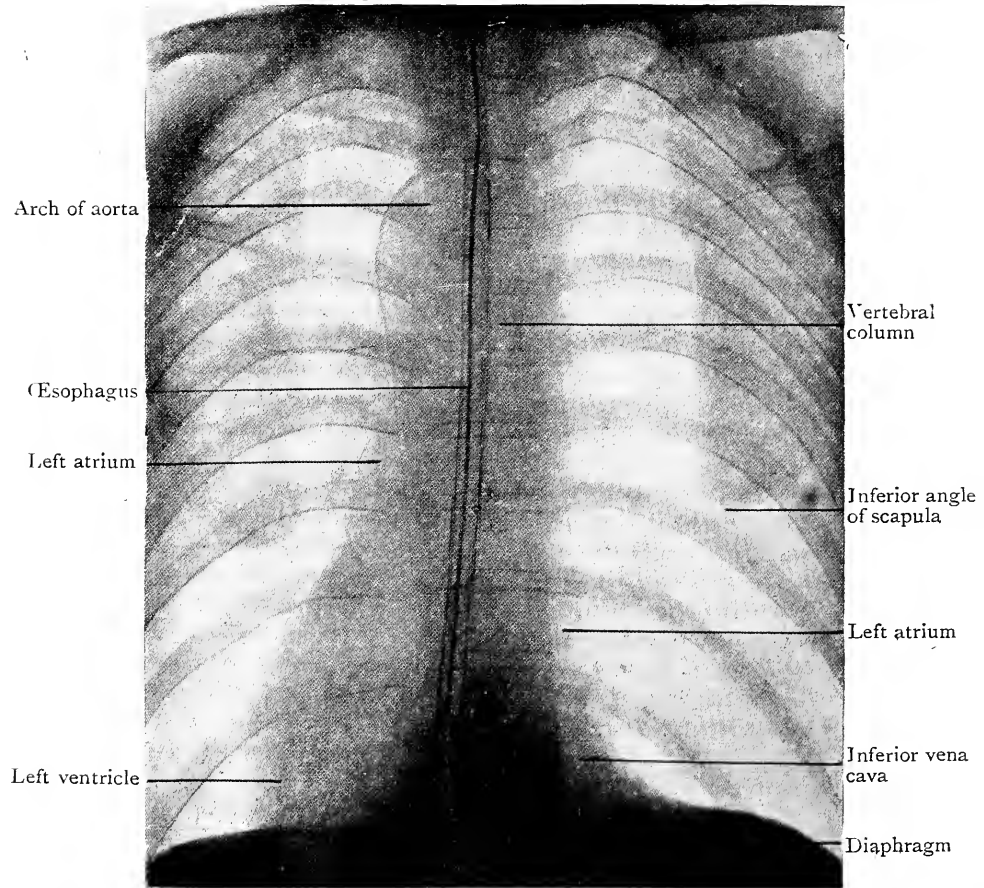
Radiograph of Thorax, showing the position of the Esophagus into which a bougie with a metal core had been inserted. Posterior view. (Goldesbrough.)
